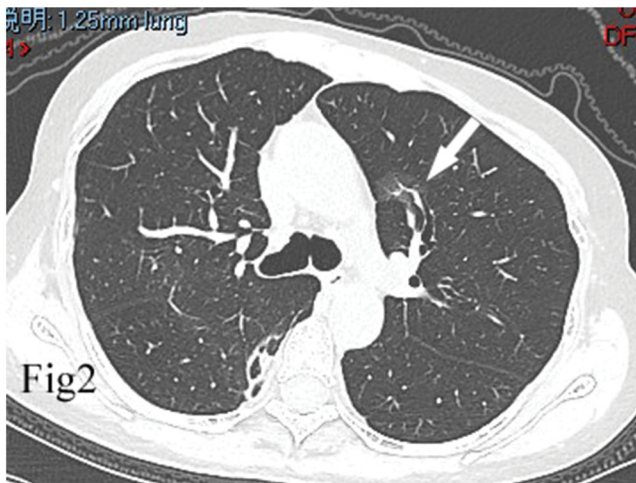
A 62 year old male patient diagnosed with mild COVID-19, with a chief complaint of “febrile for three days, cough for one day”. The CT showed a focal GGO with a central thickening of airway wall (white arrow), which we named as dandelion sign.
